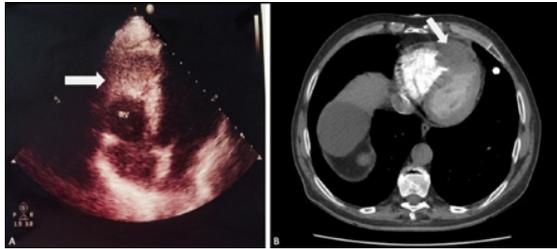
Imaging of primary cardiac sarcoma of RV (a). Echocardiography showing a large echogenic mass adherent to right ventricular apex and free wall. (b) Pulmonary CTA showing mass in the RV invading the free wall and apex.
